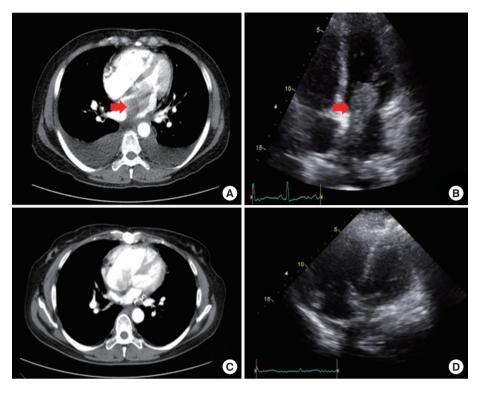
Preoperative and postoperative images of CT and TTE. (A) Preoperative CT scan showing the stalk of the tumor arising from the posterior wall of the LA (arrow). (B) Preoperative echocardiography showing a huge mobile mass in the LA obstructing mitral valve inflow (arrow). (C, D). Postoperative CT and TTE showed no remnant mass. CT = computed tomography, TTE = transthoracic echocardiography, LA = left atrium.
